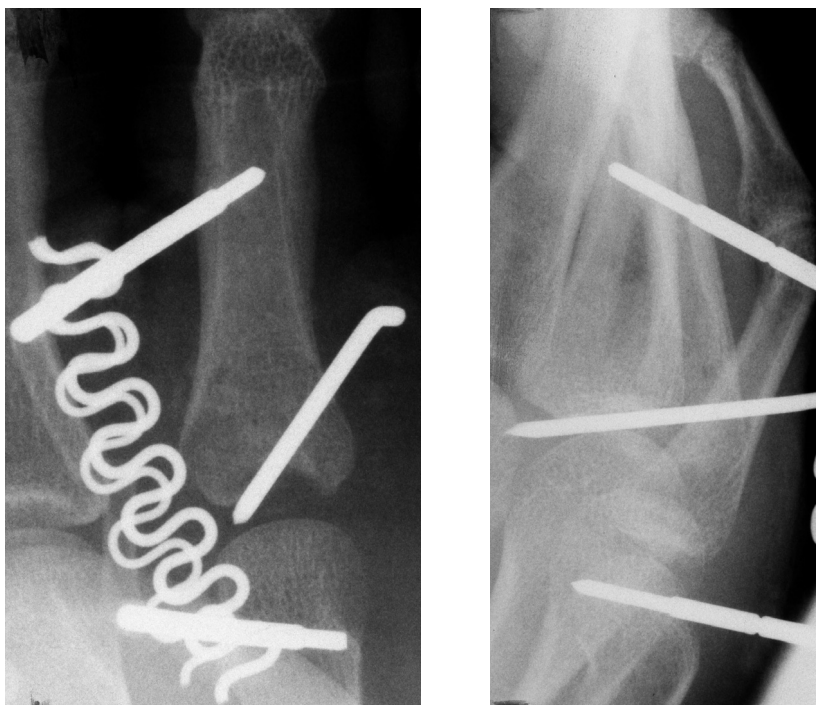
Antero-posterior (a) and lateral (b) radiograph of the fracture following limited internal fixation with a Kirschner wire and S-Quattro application
